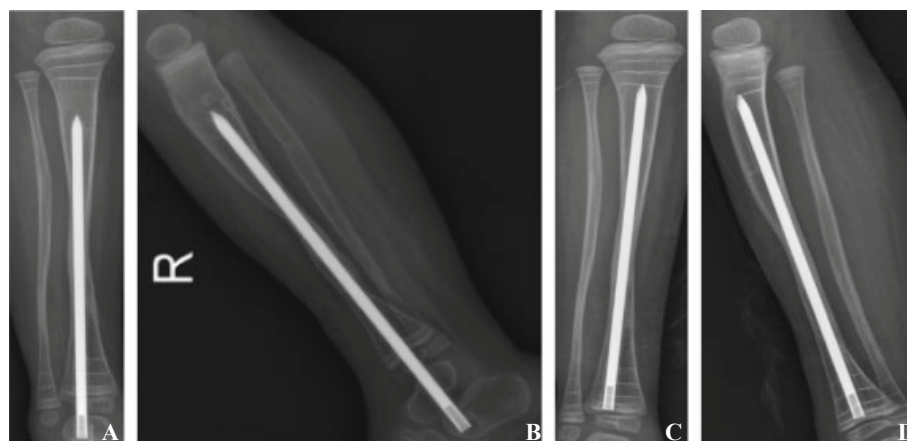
A: Anteroposterior X-ray of 1 year post operation shows solid union of the pseudarthrosis with good alignment of the tibia; B: Lateral X-ray of 1 year post operation; C: The anteroposterior X-ray of the last follow-up; D: The lateral X-ray of the last follow-up.
